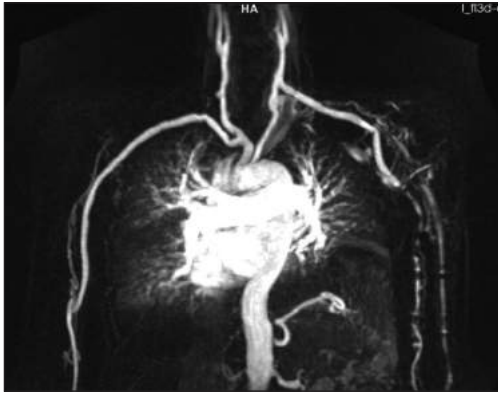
Magnetic resonance imaging: Biological graft of left carotico-subclavian bypass and right innominate artery to axillary artery bypass are patent.
